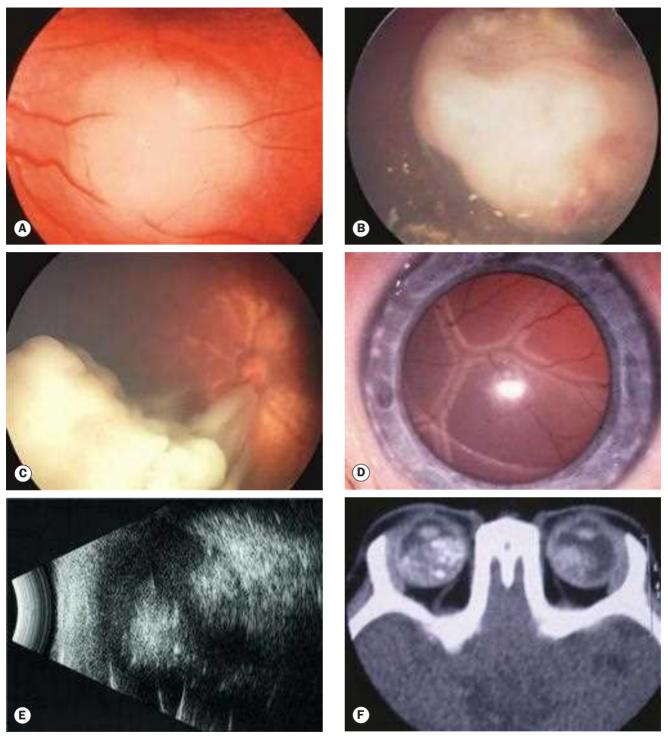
Retinoblastoma. (A) Intraretinal tumour; (B) endophytic tumour with vitreous seeding; (C) mixed endophytic and exophytic growth; (D) total retinal detachment; (E) B-scan showing echoes from calcification; (F) axial CT showing bilateral tumours with calcification (Courtesy of B Dixon-Romanowska – fig. B; M Parulekar – fig. C; K Nischal – fig. F)
